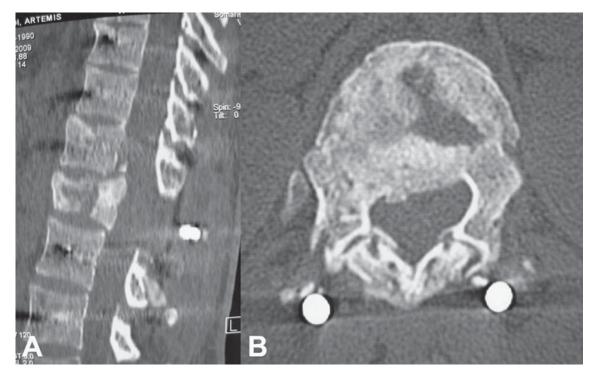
Postoperative (A) sagittal and (B) axial CT scan of the thoracolumbar spine show decompression of the spinal canal.
